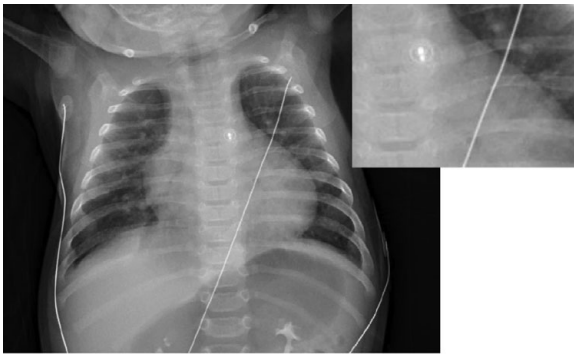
Portable chest X-ray of a four-month-old male after PDA Amplatzer device closure.
